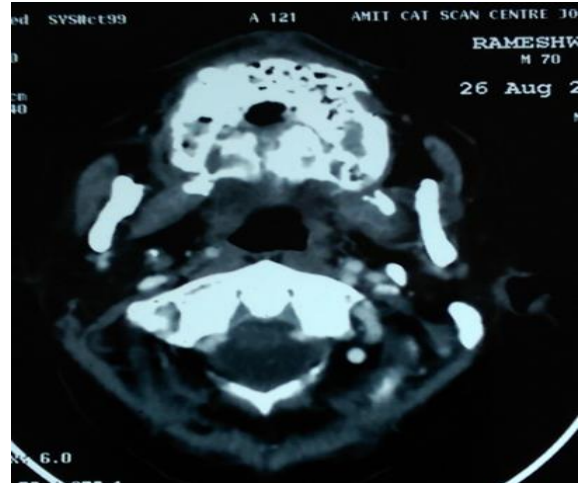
CT showing palatal perforation.
